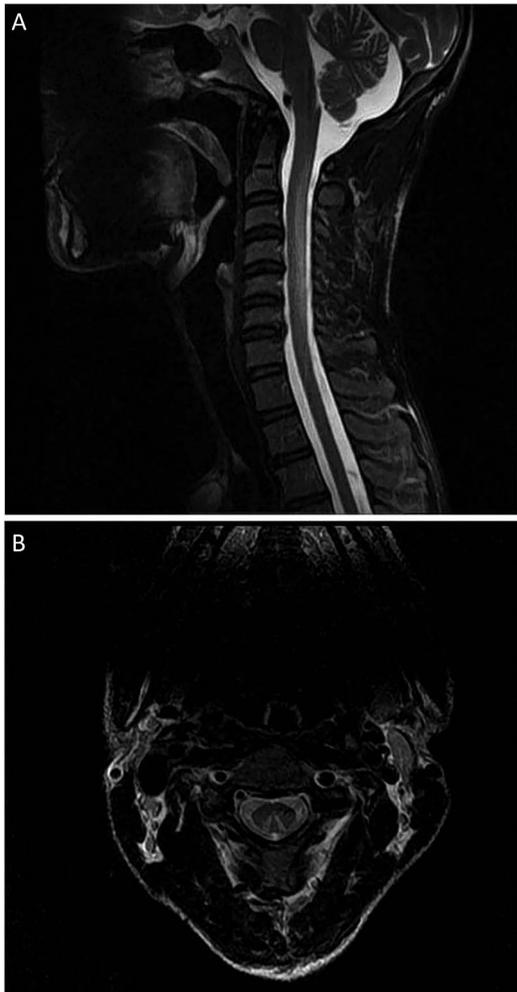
(A) T2-weighted (T2W) sagittal section MRI of the cervical spine showing hyperintensity involving the posterior columns from C2 to C7 level. (B) Axial T2W cervical spine MRI showing a typical inverted 'V'-shaped hyperintensity.
